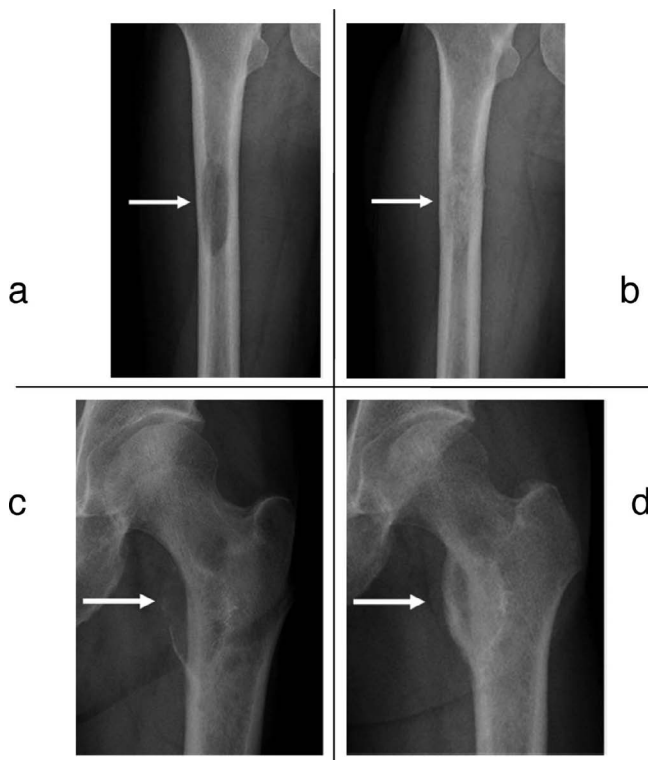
Representative Radiographs. a) Radiograph before radiotherapy showed lytic metastasis. b) After radiotherapy, it appeared to be a 'complete filling in' and was categorized as CR. c) Radiograph before radiotherapy showed lytic metastasis. d) After radiotherapy, it appeared to be a 'sclerotic rim' and was categorized as PR.
